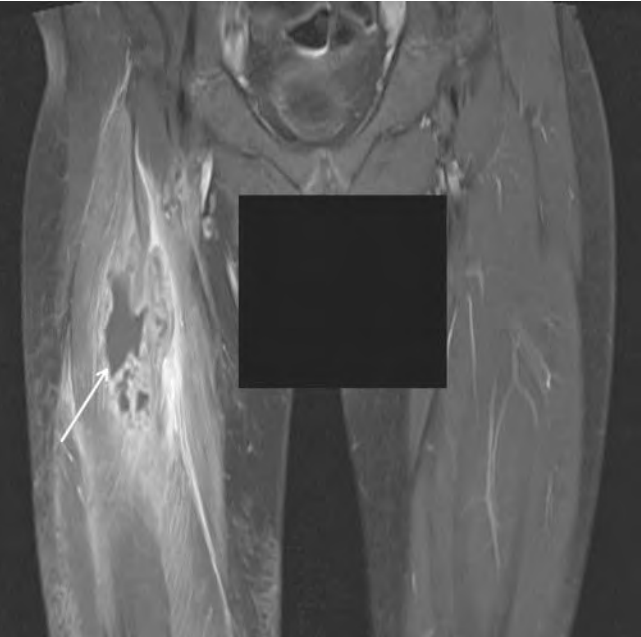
Magnetic resonance image (T1 fat sat post-gadolinium) of the thighs in patient 2 revealing a complex collection centred in the right rectus femoris muscle (arrow) with surrounding myositis with inflammatory change, which partially extends into the remainder of the anterior compartment
